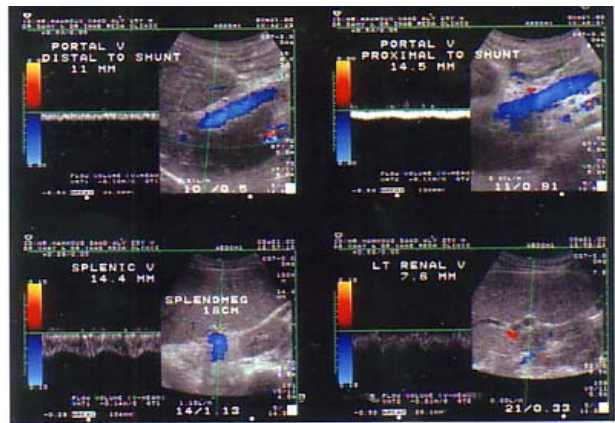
Postoperative color Doppler showing evidence of patent PCS-graft (decreased flow in the portal vein distal to the shunt).
